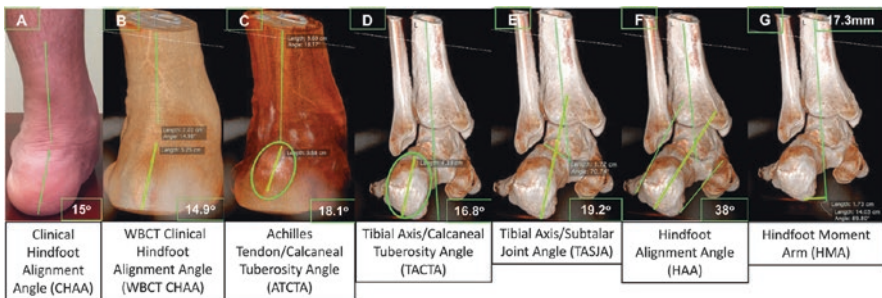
Example of measurements performed: (a) Clinical hindfoot alignment angle (CHAA); (b) weight bearing computed tomography clinical hindfoot alignment angle (WBCT CHAA); (c) Achilles tendon/calcaneal tuberosity angle (ATCTA); (d) tibial axis/calcaneal tuberosity angle (TACTA); (e) tibial axis/subtalar joint angle (TASJA); (f) hindfoot alignment angle (HAA); (g) hindfoot moment arm (HMA)
